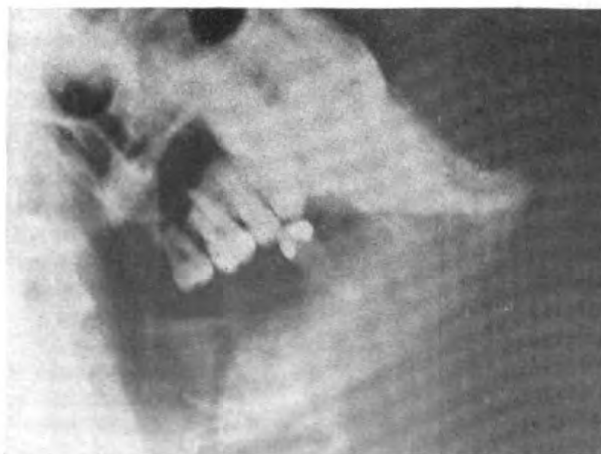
Roentgenographic view following open operation for direct bone wiring. Fragments are held in good position. Mesial root of lower molar tooth has been removed.*
